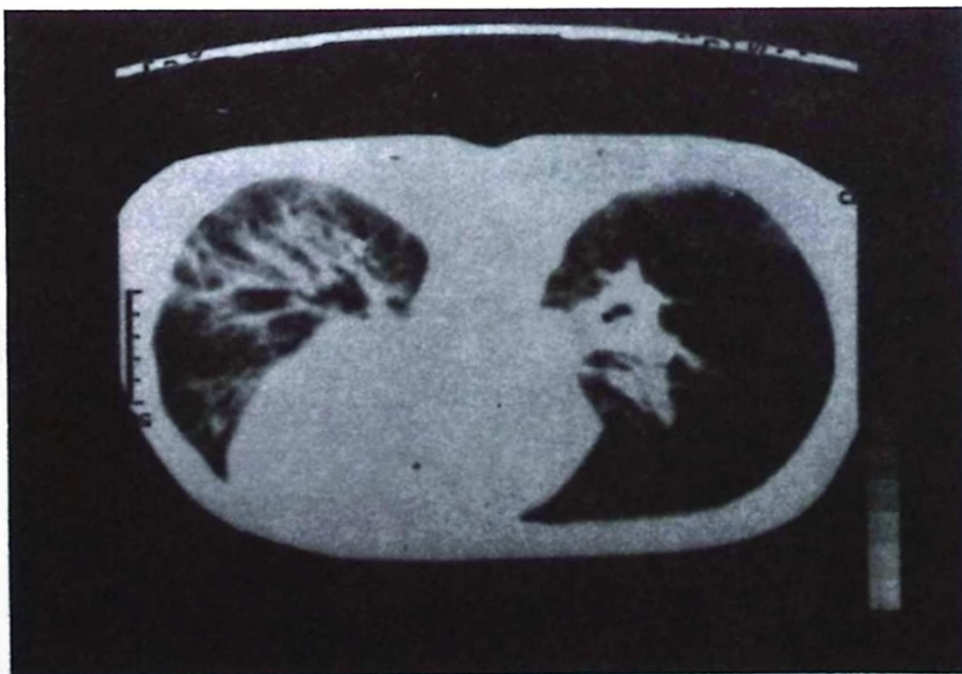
Coronal section of thoracic computed tomography (CT). Diffuse miliary infiltrates are present, especially on the right side, with patchy consolidation.
